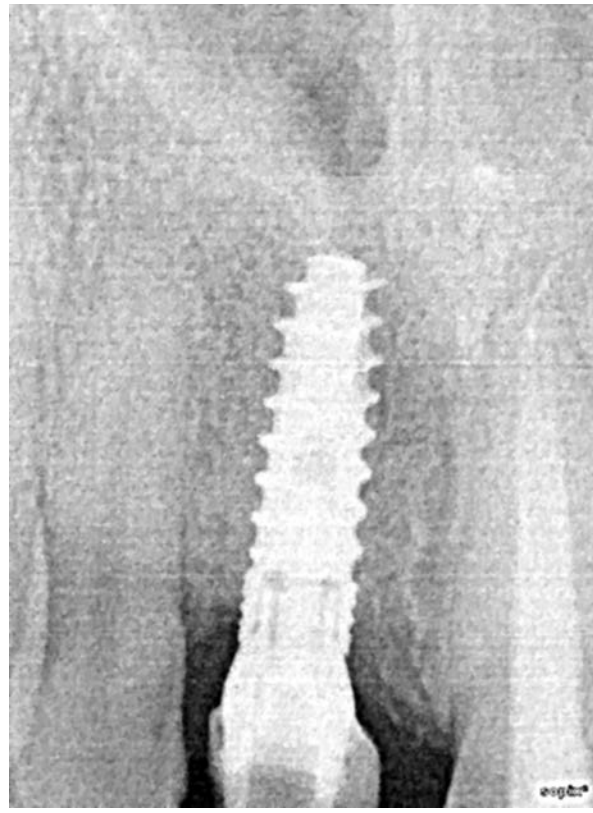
Radiograph three months after implant placement.
